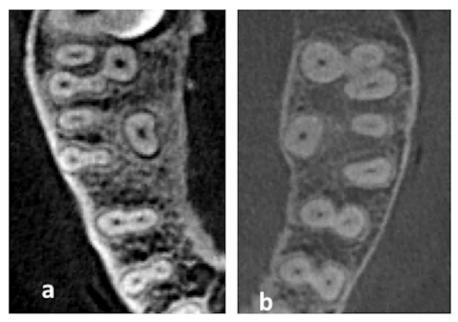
CBCT axial sections showing maxillary molars with 4 canals and premolars with 2 canals (a); and mandibular molars with 3 canals and premolars with 2 canals (b)
